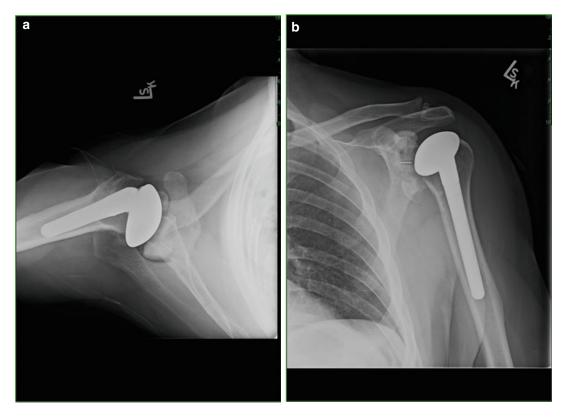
Axillary (a) and AP (b) x-ray views of a left shoulder in a patient with early failure of a lesser tuberosity osteotomy. The tuberosity has migrated medially and inferiorly
